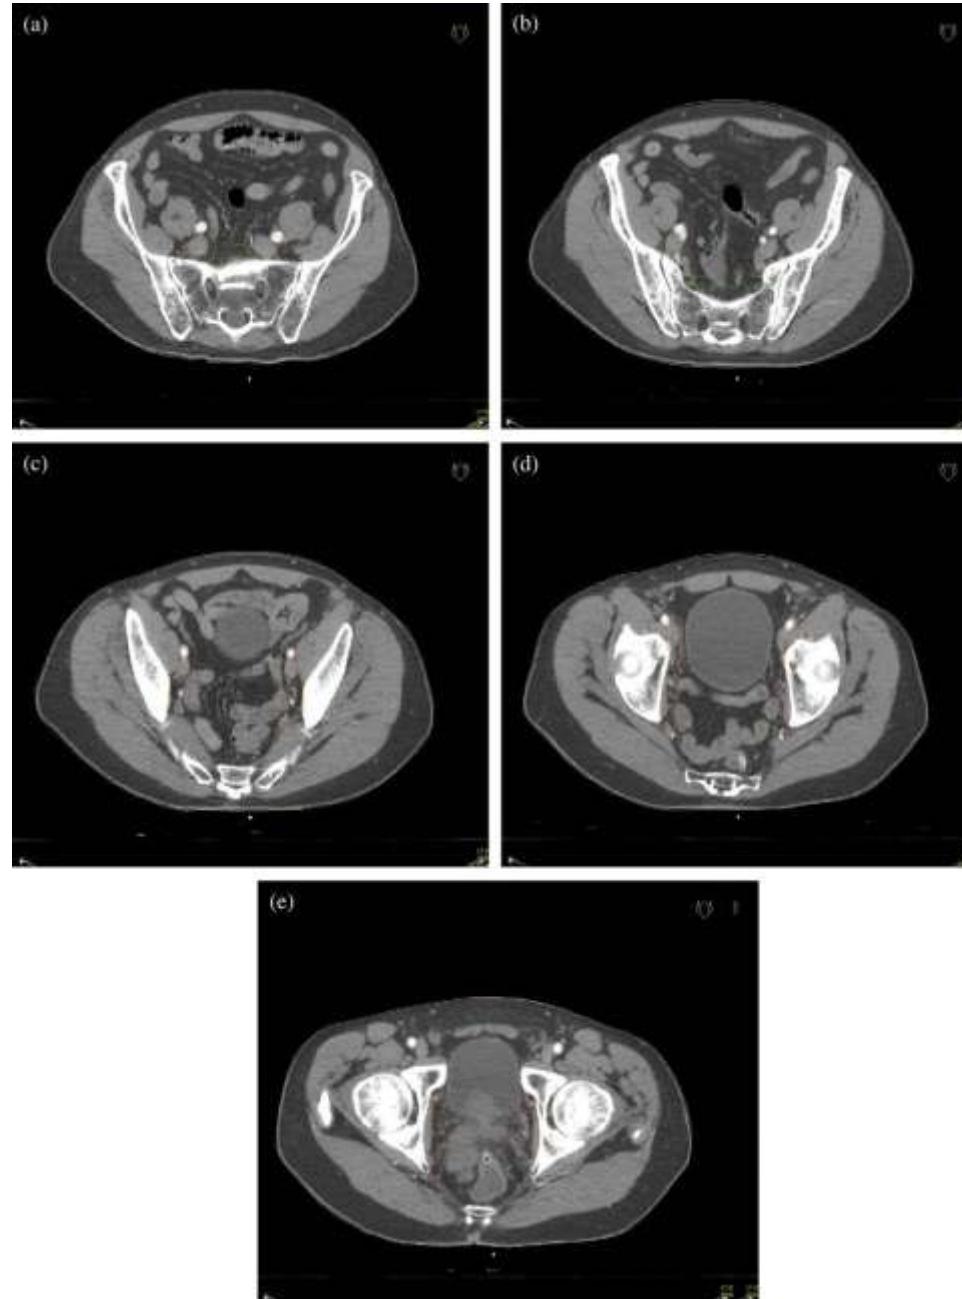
Representative pelvic lymph node clinical target volume (CTV) contours from consensus computed tomography.
